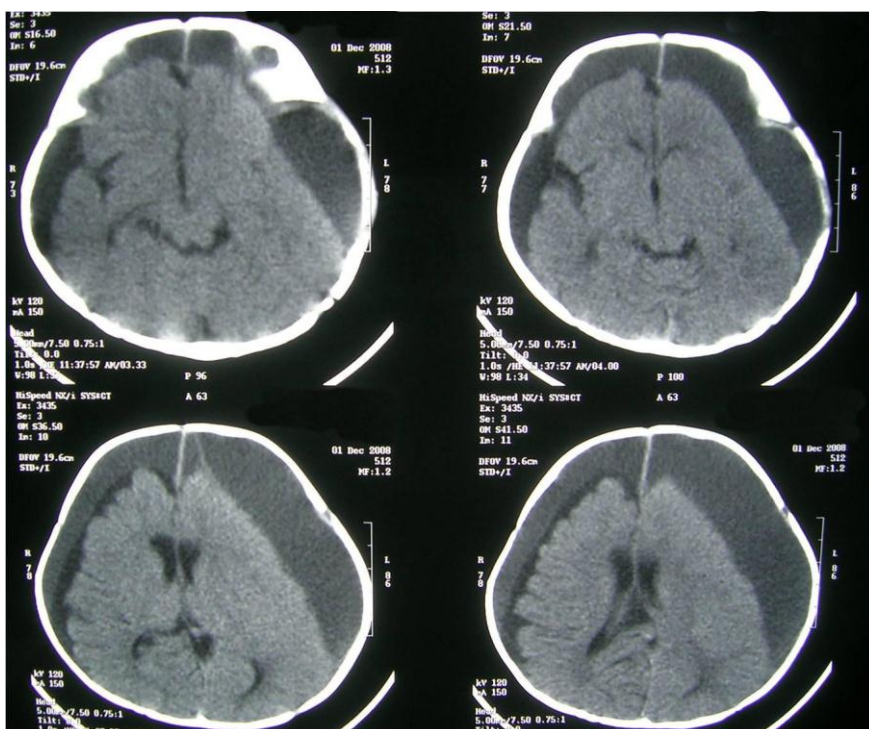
A computed tomography (CT) of the head
